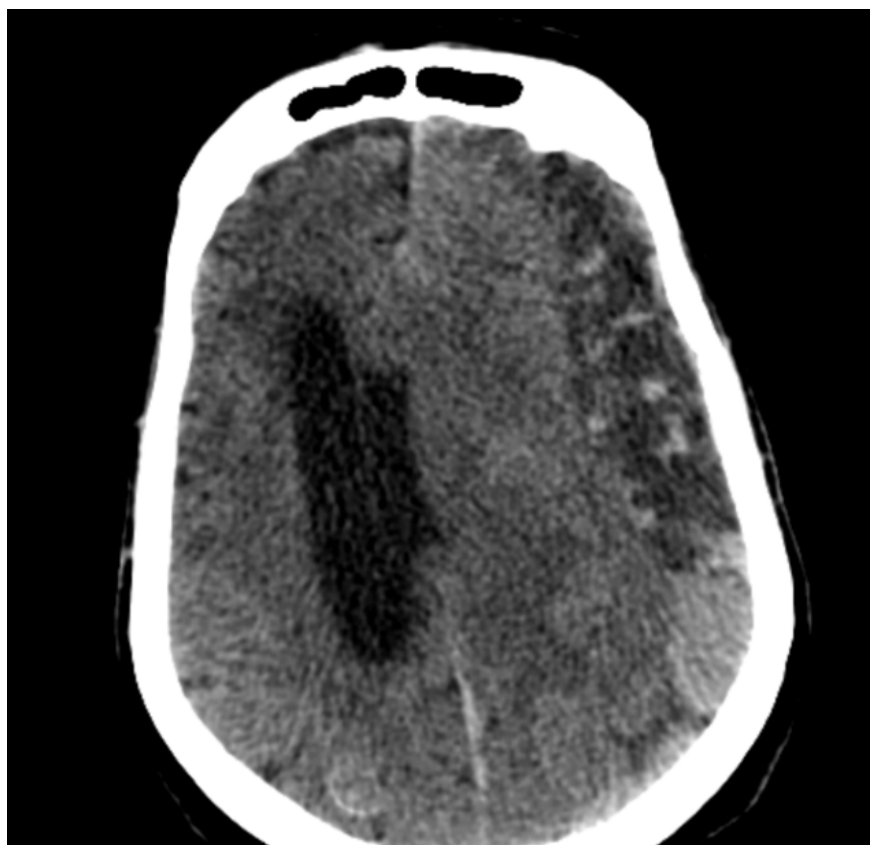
non enhanced head CT scan image showing a left heterogenous SDH with brain herniation.
